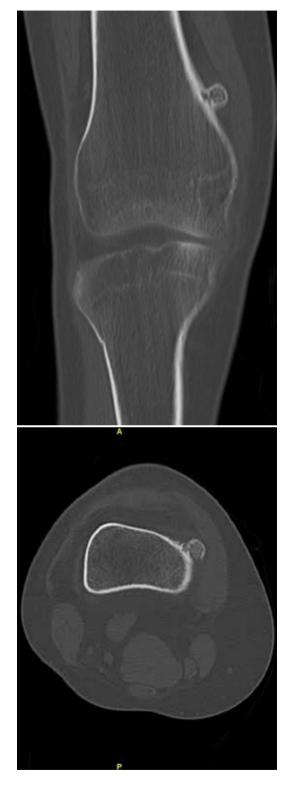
CT findings. Coronal and axial images show a lesion in contact with the medial aspect of the femoral metadiaphysis, surrounded by cortex. Around the lesion was recognized a slight thickening of the cortex
